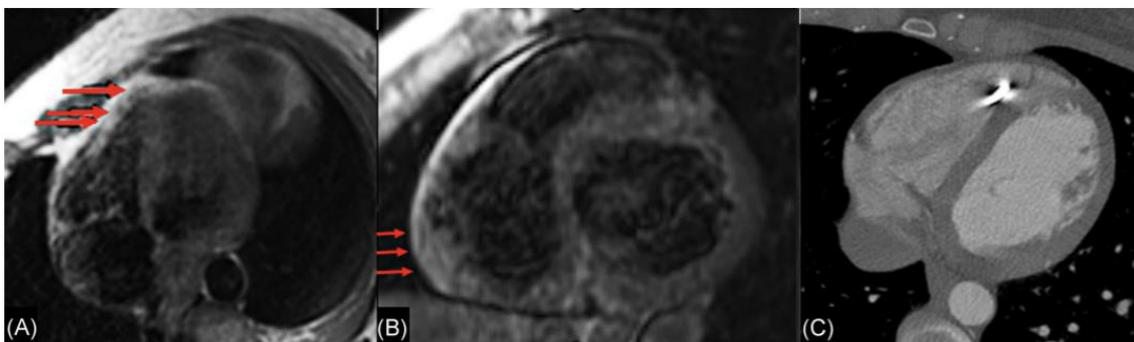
Figure x Representative CMRI (panel A, B) and CT (panel C) images of 24-year-old male misdiagnosed with ACM on CMRI. Fatty infiltration was reported to be
